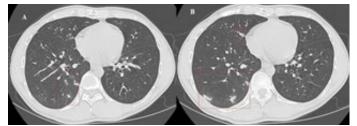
Images in a 39-year-old male who is partially vaccinated and has no comorbidities. He complained of fever for one day and cough for more than a week with a sore throat and muscle pain. The highest temperature was 39°C. (A-B) The chest CT scan reveals bilateral multifocal nodules without consolidation. The CT-SS score was 2, and this case was classified as an atypical appearance of COVID-19 based on the RSNA chest CT classification system.
